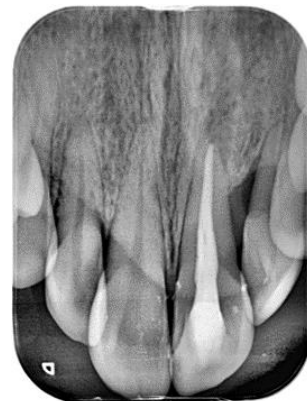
Postoperative retroalveolar radiograph.
